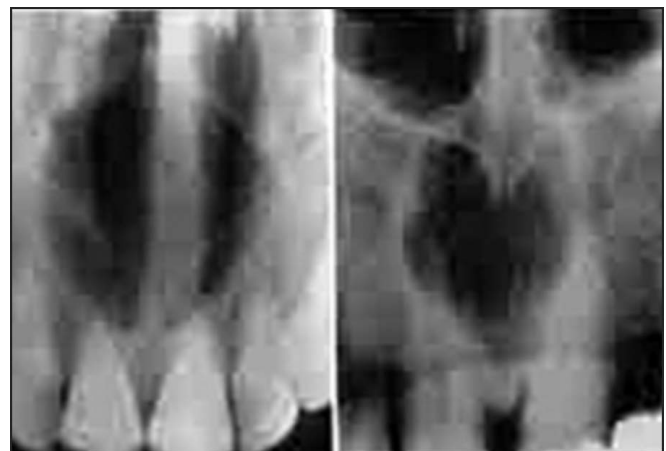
X-ray appearance of nasopalatine cysts showing the peculiar radiolucent heart shape area
